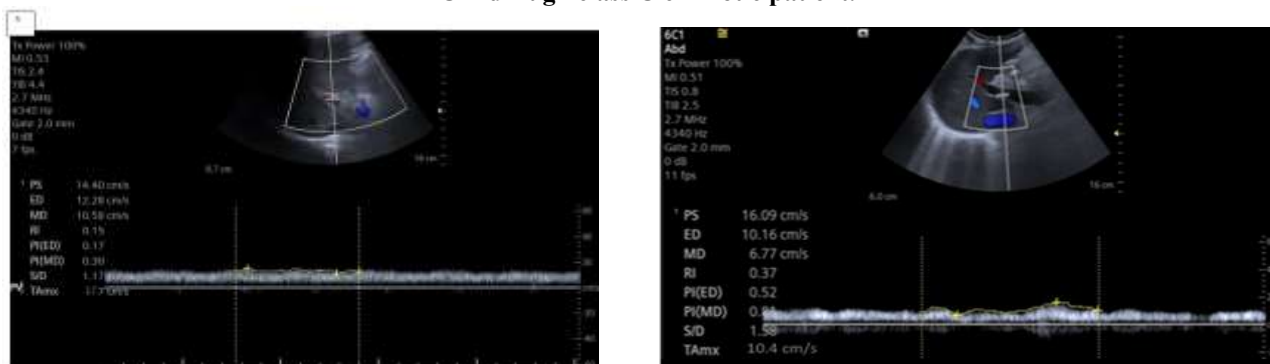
Representative portal venous spectral Doppler assessment. (A) Preserved portal venous spectral signal in the normal example. (B) Reduced mean portal vein velocity of approximately 11.4 cm/s in a cirrhotic patient.
